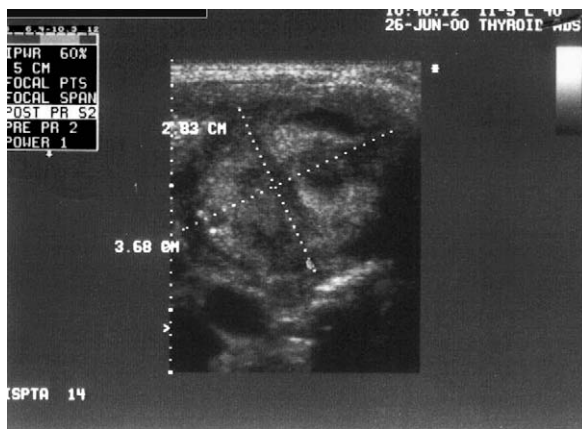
Ultrasonographic image of the right thyroid lobe mass.
